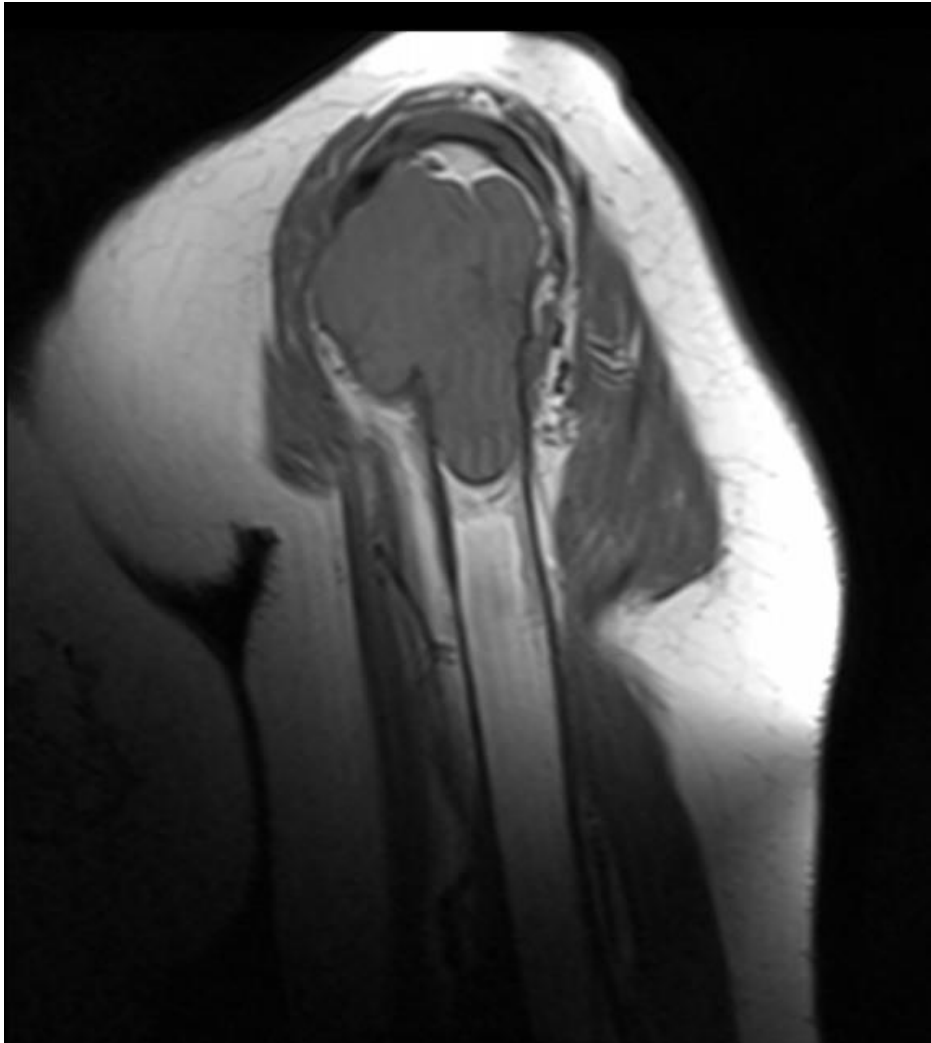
MRI of the left humerus
